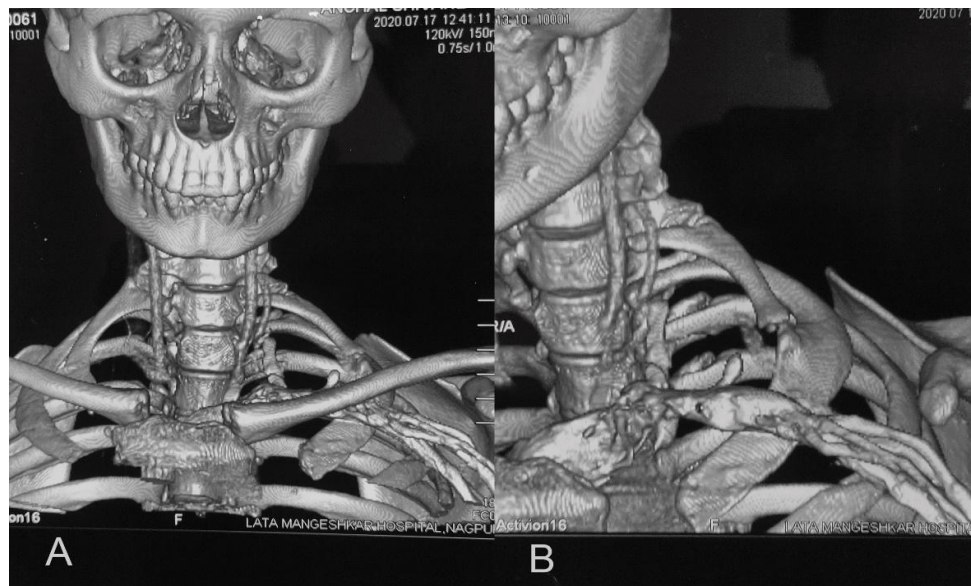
(A) 3D CT Thorax showing anomalous left first thoracic rib having pseudoarthrosis with bony prominence of second rib, (B) relation of brachial plexus and subclavian vessels with bony anomaly.
